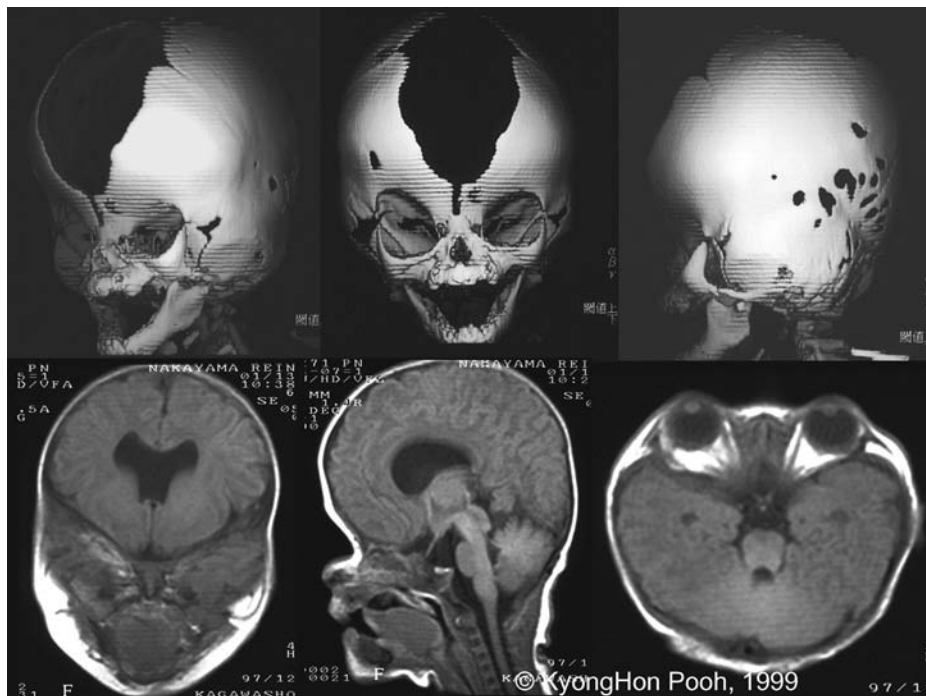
Three-dimensional reconstruction CT and MR images of Apert syndrome (the same case as in Figure 39.51). (Upper) Three-dimensional reconstruction CT. Fusion of bilateral coronal suture and squamous suture, defect of frontoparietal cranial structure, and craniofacial bony dysplasia are recognizable. (Lower) Postnatal MR images. Marked shortening of anterior cranial fossa is seen. Mild ventriculomegaly and absent septum pellucidum are seen.
